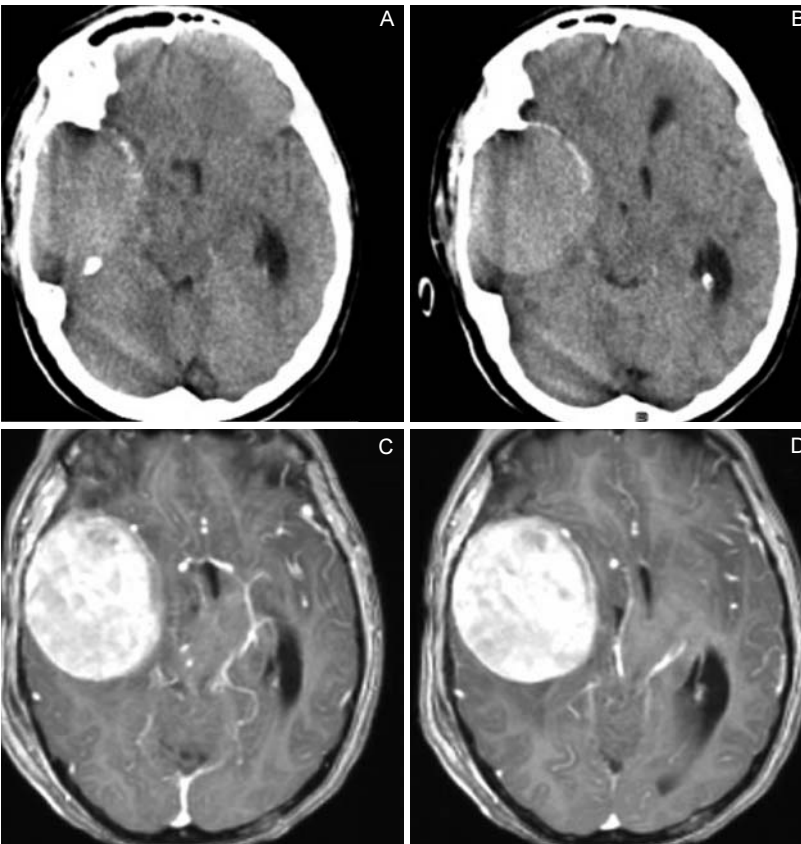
67 year old female with meningioma lesion in emergency room for epilepsy. Section of CT scan of the skull, without contrast, and axial sequence of MRI in T1 with gadolinium.
